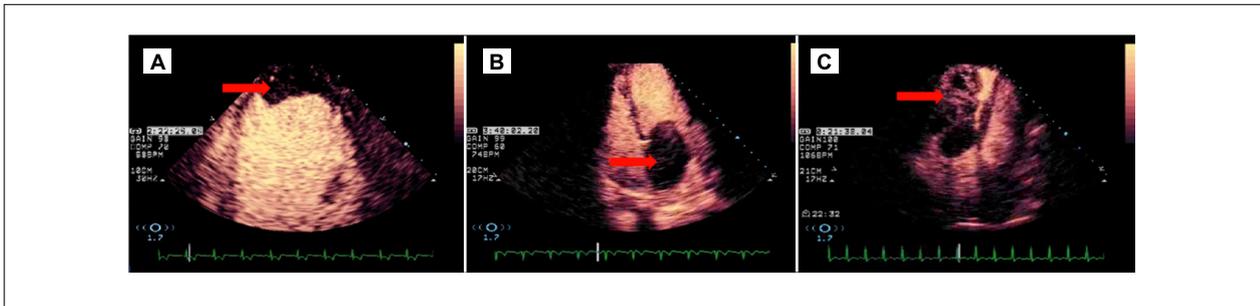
(A) Apical four-chamber plane on sample myocardial perfusion echocardiography focused on the right ventricle showing an unenhanced mass consistent with a thrombus. Video 3A. (B) Apical four-chamber plane of a left atrial myxoma mass with almost no enhancement. Video 3B. (C) Apical four-chamber plane of a right ventricle metastasis. The hypervascular mass demonstrates increased perfusion and areas of necrosis. Video 3C.
